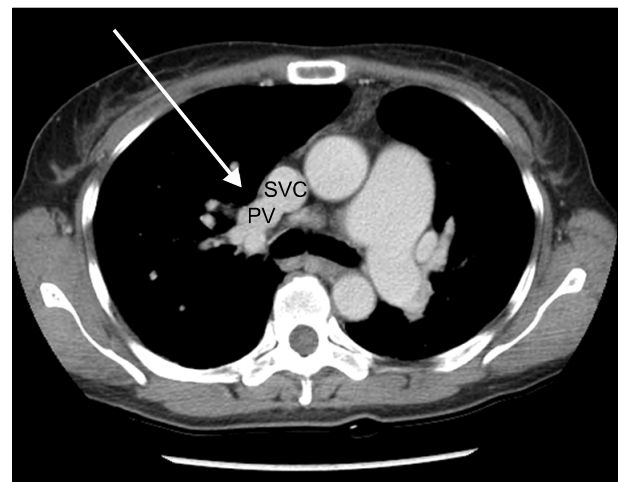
Chest CT shows the upper right pulmonary vein draining into the superior vena cava.
